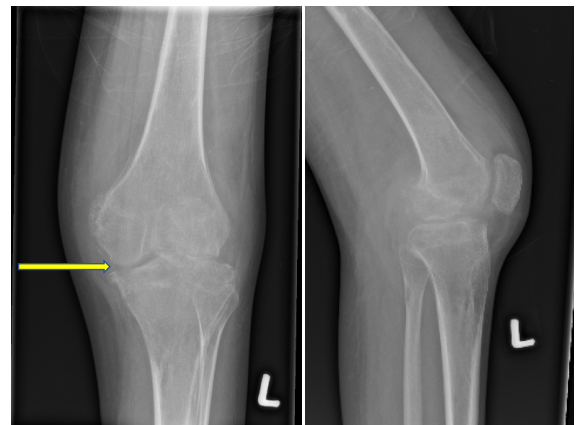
Knee X-ray upon presentation at our centre show joint space loss with the sclerosed distal femur and tibia bone (yellow arrow)
